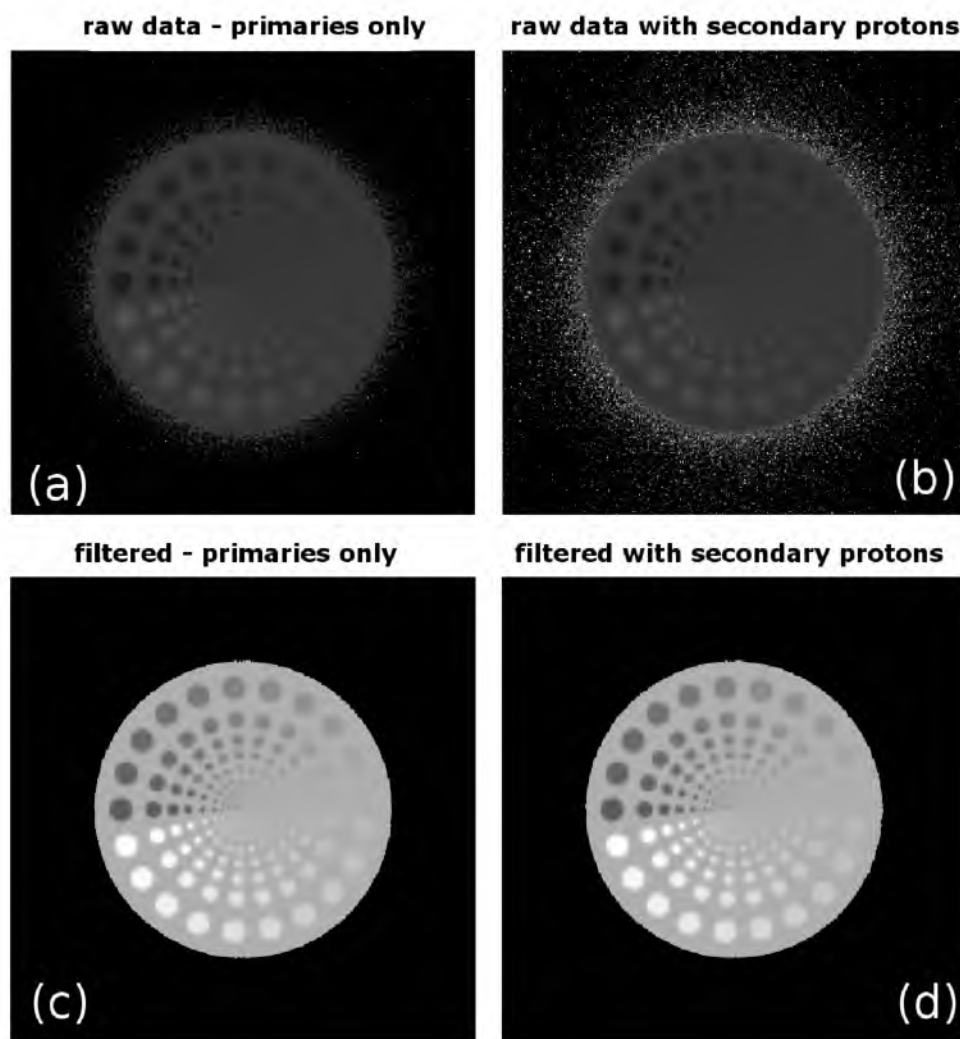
Reconstructed 490 MeV proton radiographs for (a) primary protons only, (b) primary and secondary protons, (c) primary protons with angular and energetic cuts, and (d) primary and secondary protons with angular and energetic cuts. All images were optimized to use the full gray scale, hence resulting in significant contrast difference.
